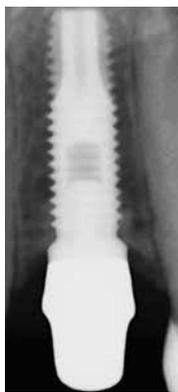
Radiographic initial condition of implant 22.
